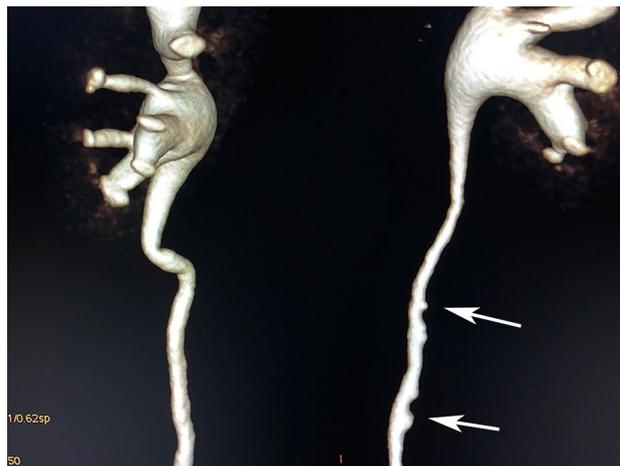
Ureteral pseudodiverticulosis. A volume-rendered excretory phase contrast-enhanced posterior CT image demonstrates multiple tiny outpouchings projecting from the mid left ureter (arrows) in this patient who had previously had a cystectomy with creation of a neobladder for treatment of bladder cancer. The pseudodiverticula are easier to identify on three-dimensional reconstructed CT than on axial images
